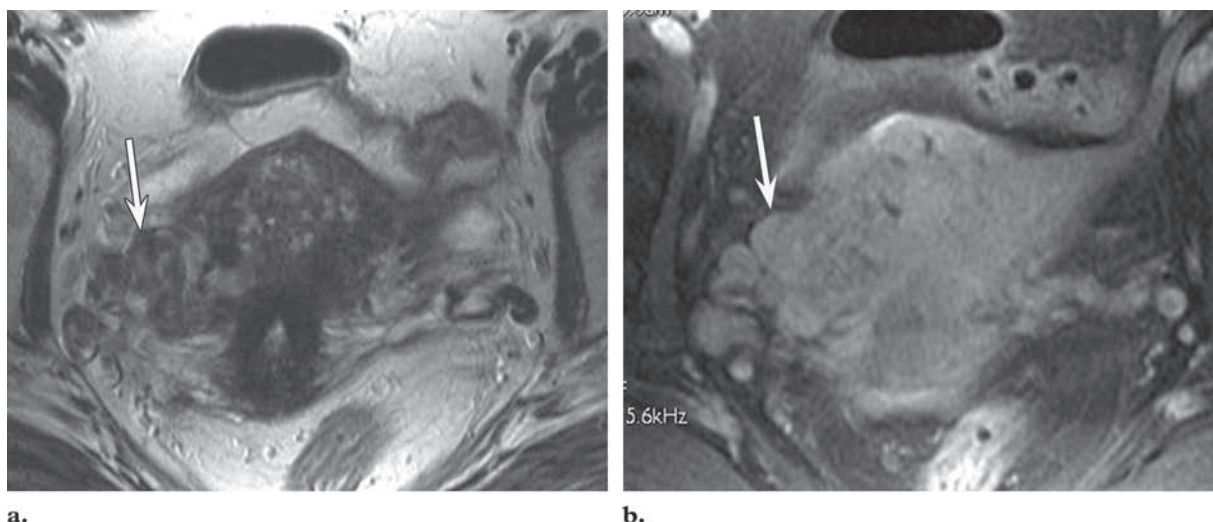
Intravenous leiomyomatosis in a 40-year-old woman with a previous diagnosis of multiple uterine leiomyomas. Axial T2-weighted (a) and axial contrast-enhanced T1-weighted (b) fast SE images of the pelvis show serpentine, cordlike growths (arrow) within the lumina of the parametrial veins. The lesions have low to intermediate signal intensity in a and show enhancement similar to that of the adjacent myometrium in b.
